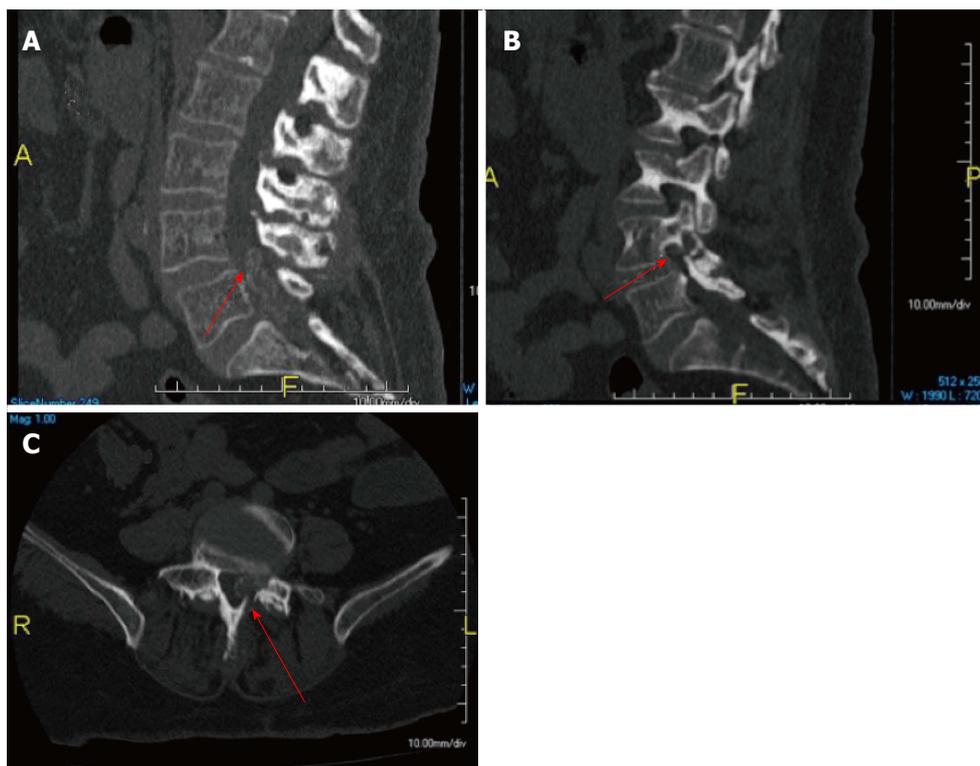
Computed tomography scan mid sagittal (A), left parasagittal (B), and axial (C) views showed the intraspinal lesion was calcified with erosive changes at the left L4-5 facet joint and L4 lamina (arrows).
